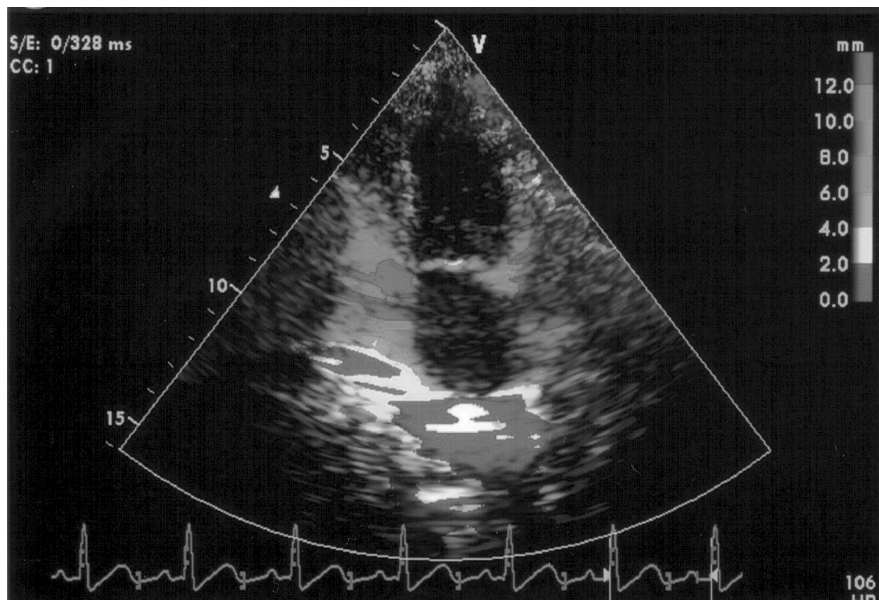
Apical four-chamber view images with tissue tracking.
